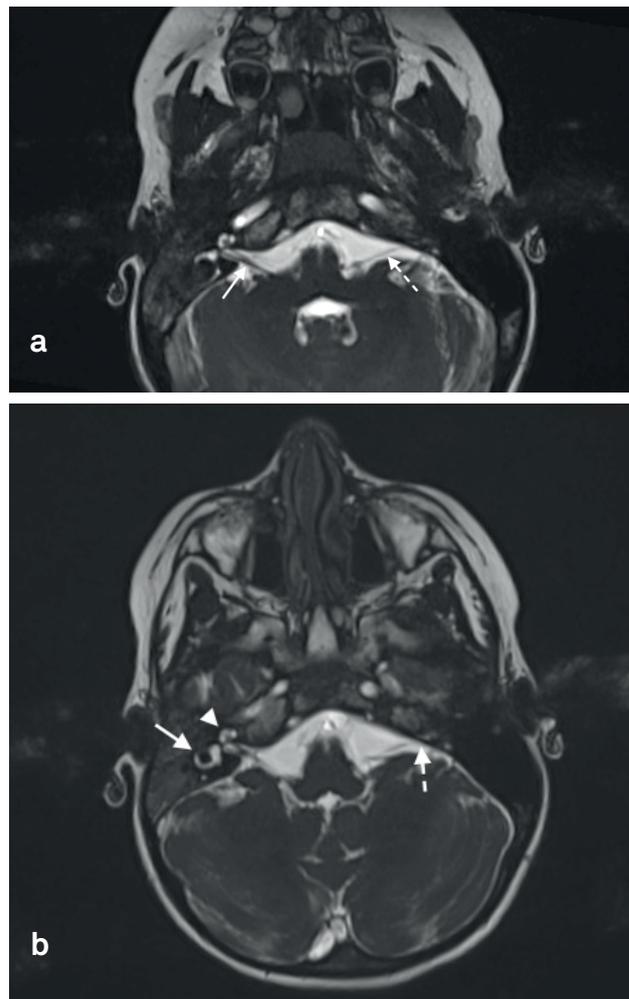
a) The right arrow on the axial T1-weighted MR image shows the seventh and eighth nerve complexes and the left dashed arrow shows the seventh nerve. The eighth nerve is not monitored in the left ear. b) Semi-circular canals and cochlea on the left are shown with the arrows on the axial T1-weighted MR image. The left dashed arrow shows the hypoplastic internal auditory canal.
